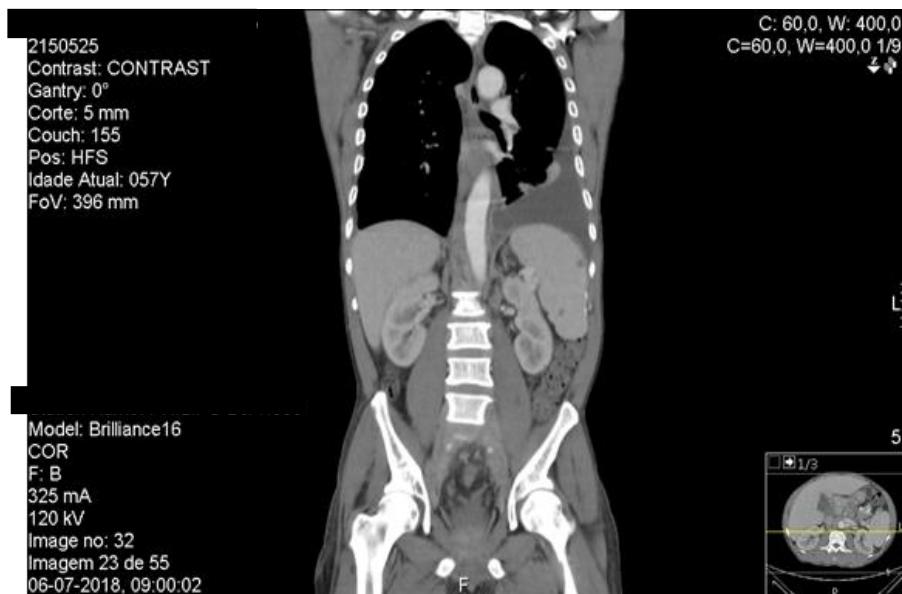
Coronal plane thoraco-abdominal-pelvic CT scan: left chylothorax and hepatosplenomegaly.
